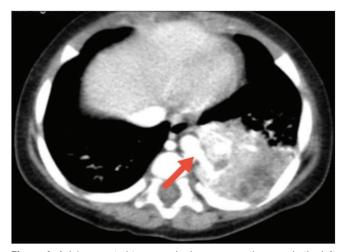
Axial computed tomography image, a cystic mass in the left lower lobe and a branch of the thoracic aorta (red arrow) extending into the lesion
